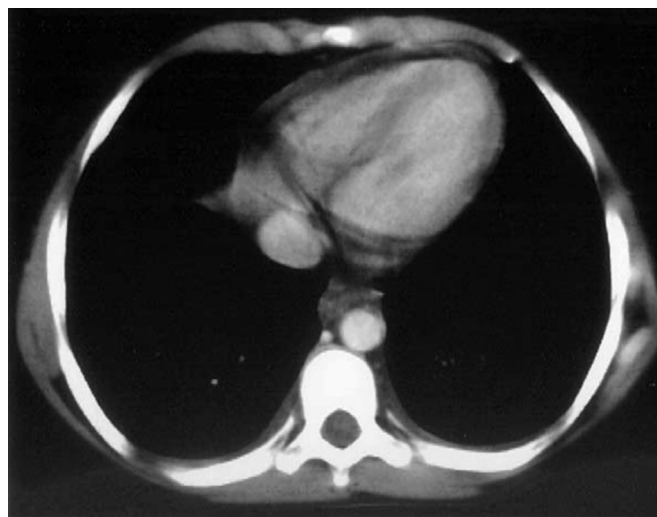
CT scan of an FMF patient demonstrating pericardial thickening and bilateral small pleural effusions. Adapted from Ishak et al. [142].
